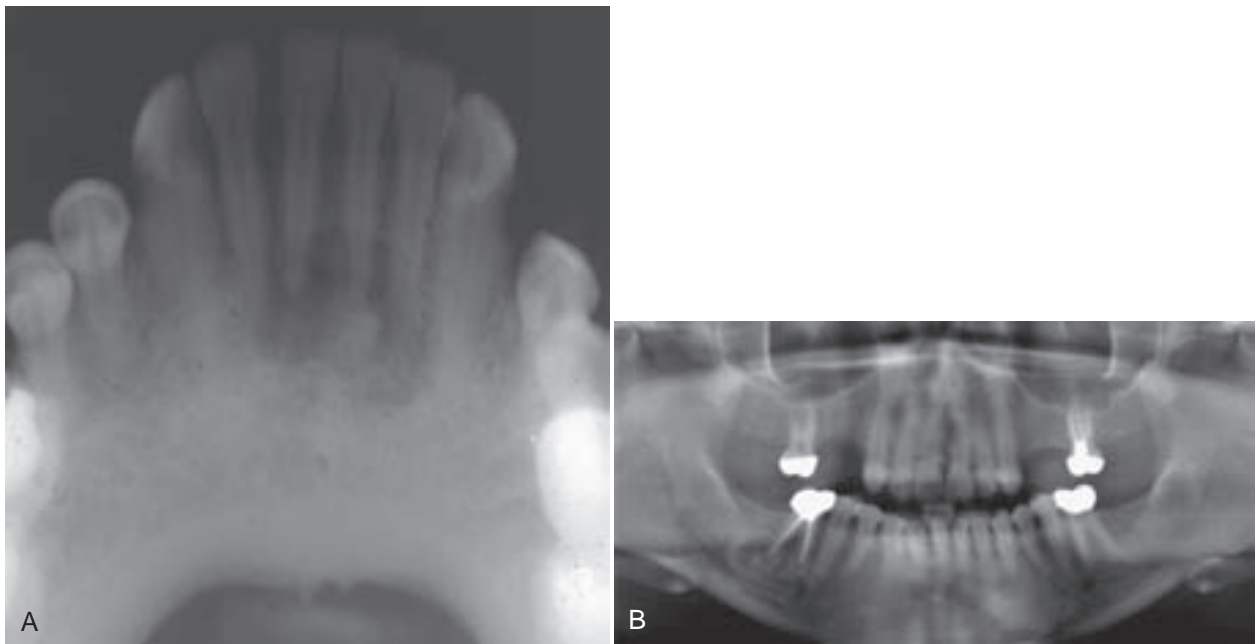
Focal cemento-osseous dysplasia. A, Variant: periapical cemento-osseous dysplasia. Radiolucency at the apices of vital mandibular anterior teeth with faint opacities. B, Circumscribed radiolucency with sclerotic rim and central calcification around the distal root of the right mandibular first molar. (Courtesy of Dr. Rafik Abdelsayed, Medical College of Georgia, School of Dentistry, Augusta, Ga.)
